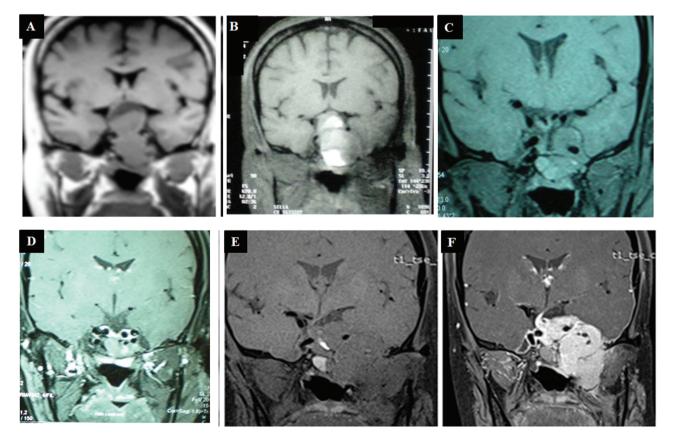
A to F, Panel of magnetic resonance imaging scans of the patient showing A, a $5 \times 3 \times 3$ -cm sellar mass extending into the suprasellar and sphenoid regions consistent with a giant macroprolactinoma; and B, showing T1 hyperintense lesions due to pituitary apoplexy in the tumor (hemorrhagic area $3 \times 3.4 \times 3.3$ cm) after 6 months of cabergoline therapy. After transsphenoidal surgery, C, the tumor residue has a right (0.7×0.7 cm) and left ($1.6 \times 1.9 \times 1.3$ cm) parasellar aspect encasing the left carotid artery and D, shows minimal to absent residue. E and F, One year later an enhancing sellar suprasellar mass ($2.1 \times 1.9 \times 2.7$ cm) extends into the left cavernous sinus, middle cranial fossa, pterygopalatine fossa, infratemporal fossa, and left cisternal part of the optic nerve encasing the left cavernous sinus.
